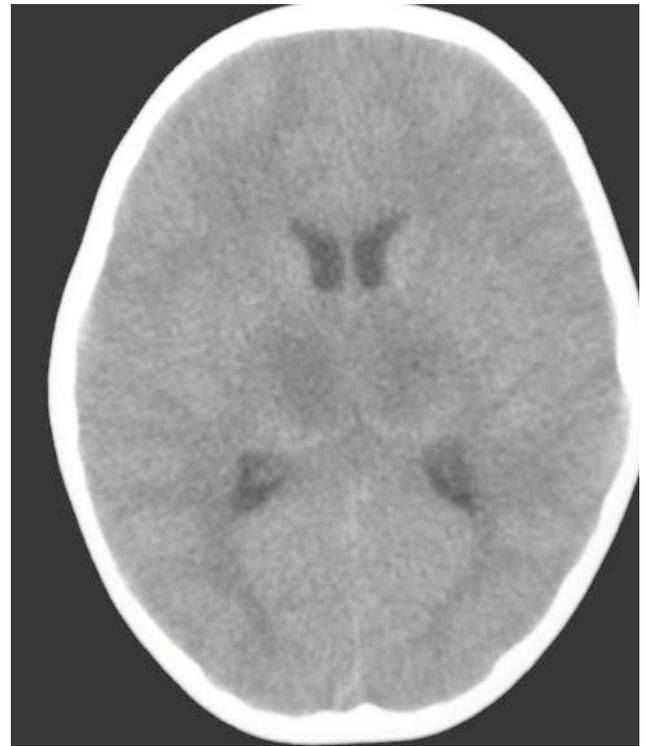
CT scan brain shows multifocal hypodense lesions in cerebellum and brainstem.
